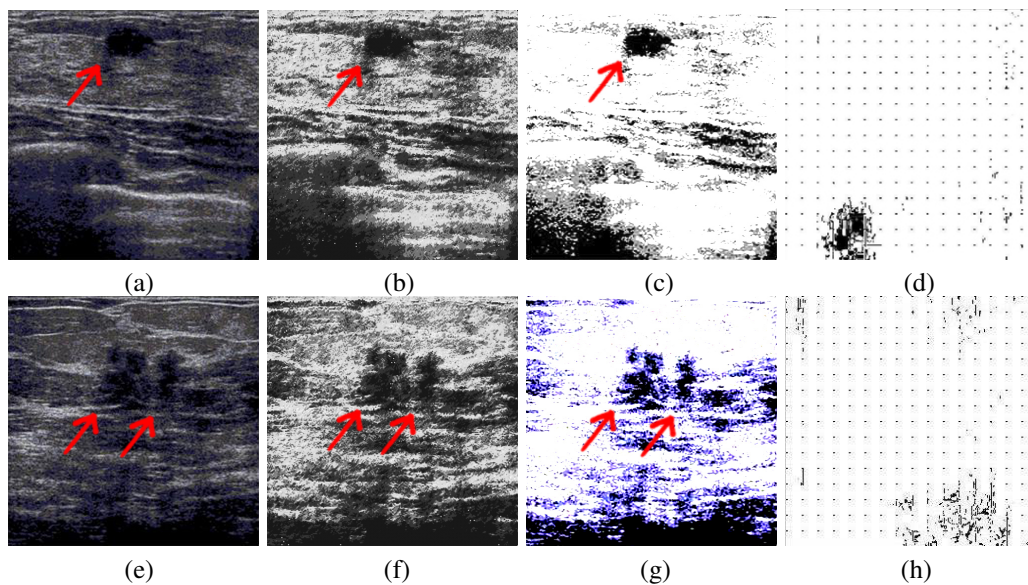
ARMA modeling and segmentation of ultrasound breast images: (a) cancerous ultrasound image; (b) 2D-ARMA[2,2,2,2] representation of (a); (c) Segmentation of (b) using an appropriate threshold; (d) 1D-ARMA[2,2] representation of (a); (e) benign tumor ultrasound image; (f) 2D-ARMA[2,2,2,2] representation of (e); (g) Segmentation of (f) using an appropriate threshold; (h) 1D-ARMA[2,2] representation of (e).
